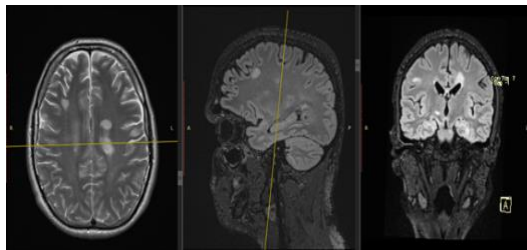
First non-specific patient, recent MRI. Multiple, cerebral, demyelinating, inflammatory lesions, suggestive of multiple sclerosis. Source: Author's elaboration
